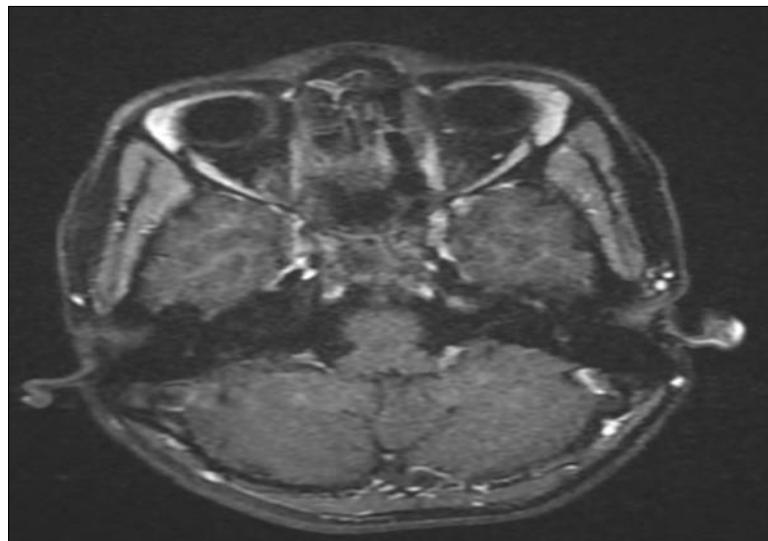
T1 GADO MRI sequence showing complete tumor regression two years after treatment
